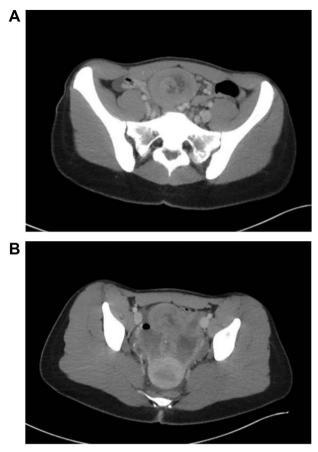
CT findings of long segment lead point.
